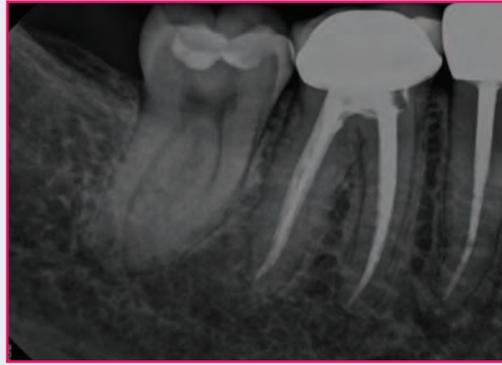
One year recall radiograph
